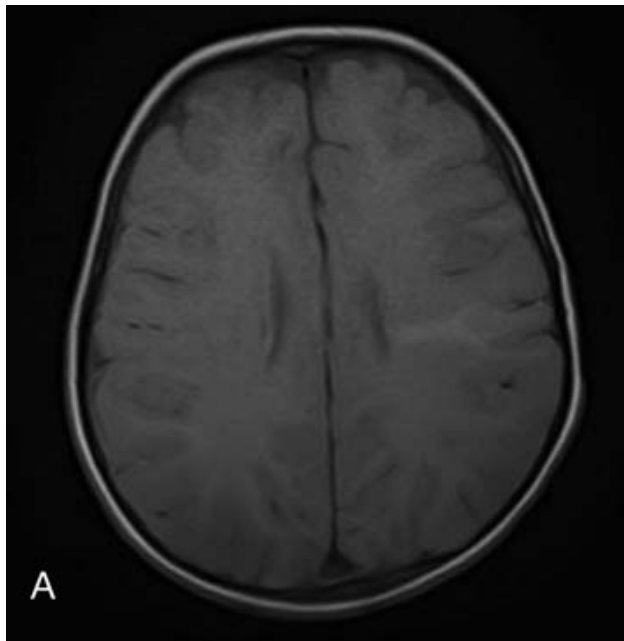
Radial bands MRI (A: T1, B: T2, C: Flair, D: T1 Post-contrast)
